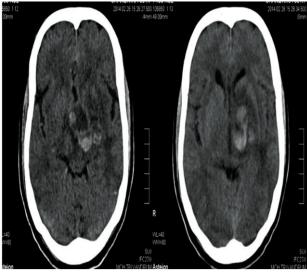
Non-contrast Computed Tomogram brain images showing hypodense supra-sellar lesion with hemorrhage extending to left basal ganglia
